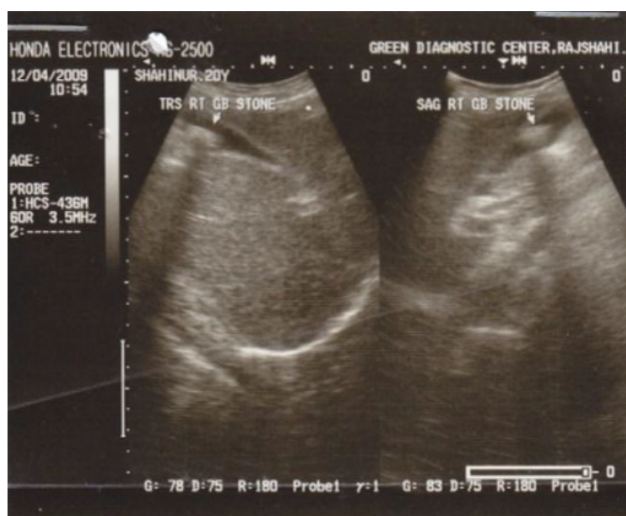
Ultrasonography showing Cholelithiasis
